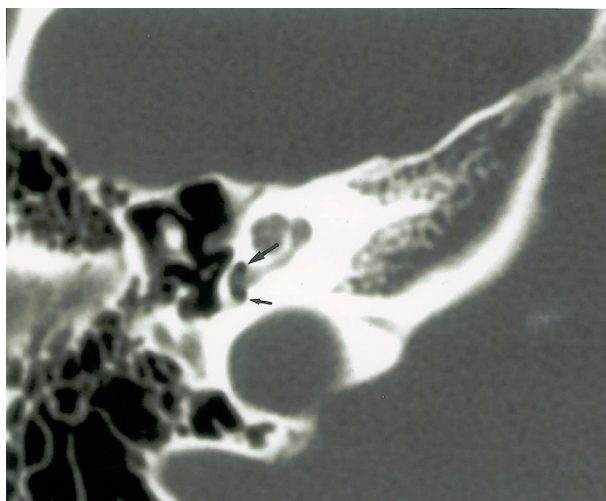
Axial high resolution CT (1mm thickness, window width 4000, center 300) of the right cochlea shows a hypodense area in the non-dependent portion of the basal turn (large arrow), with the Housefield unit -630, and the Housefield unit of round window niche (small arrow) is -650.
